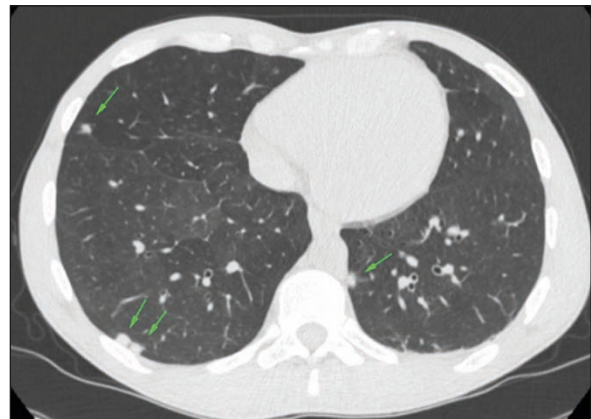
Pulmonary CT scan on day 2, showing millimetric rounded nodular lesions on both lungs (green arrows).
